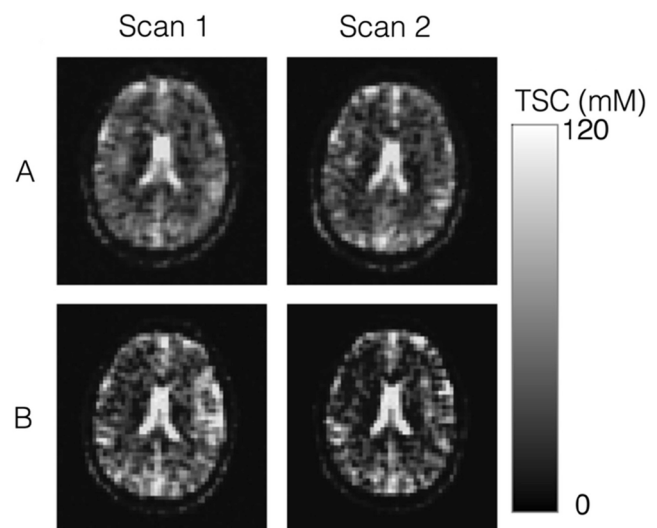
3D ^{23}Na -MRI of a healthy volunteer showing total sodium concentrations across brain regions from two different sites (A and B) and at two different time points (scan 1 and scan 2). Images demonstrate repeatability and reproducibility of the technique. Adapted with permission from Riemer *et al.* [68].
